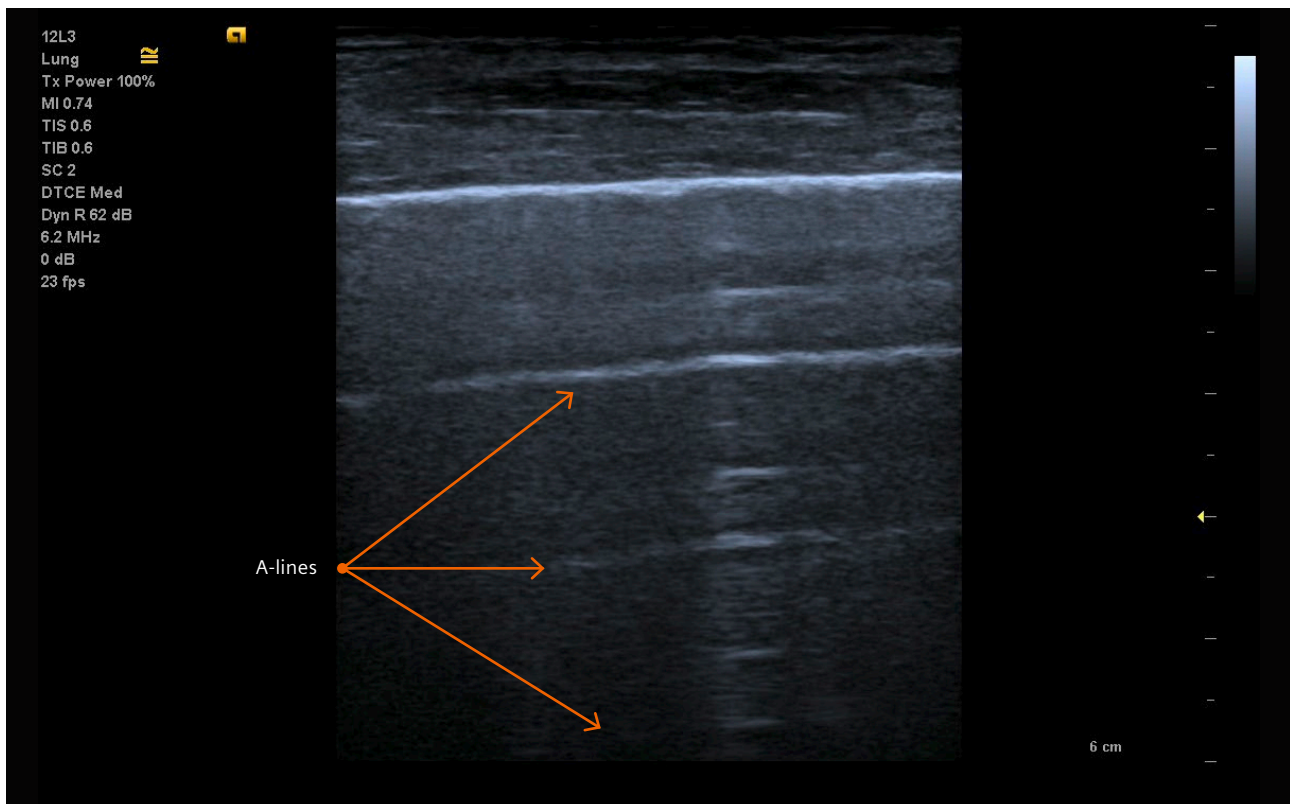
Ultrasound image demonstrating A-lines using a linear transducer. The A-lines are the bright horizontal lines deep to the pleural line. A-lines are a classic reverberation artifact.
